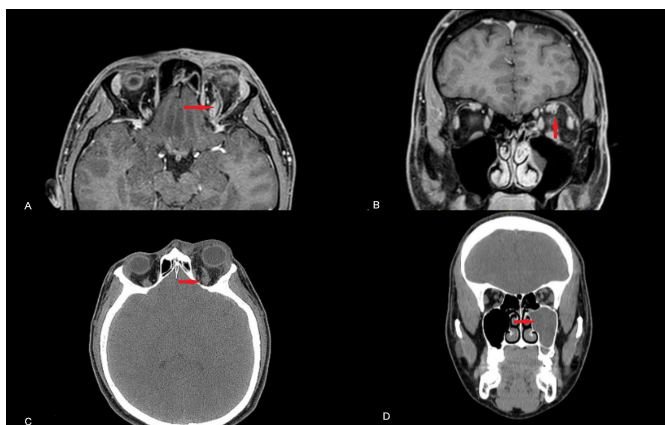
A) Contrast-enhanced MRI-T1-axial section dilation of the left SOV and a filling defect (red arrow), B) Contrast-enhanced MRI-T1-coronal section a filling defect in the SOV (red arrow), C) CT-axial section enlarged SOV (red arrow) and proptosis, D) CT-coronal section shows left maxillary sinusitis (red arrow)
